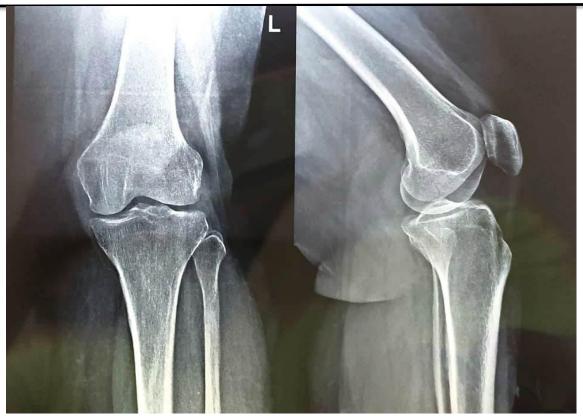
X-ray photograph of preoperative conditions showing damaged cartilage
